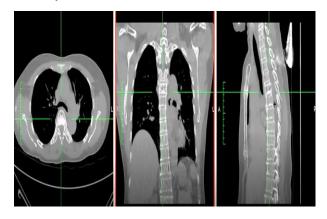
(A) Axial view CT showed bone sclerosis of vertebral body T5. (B) Coronal view showed "polka dot" sign suggests hemangioma. (C) Sagital view showed destruction of vertebral body T5
